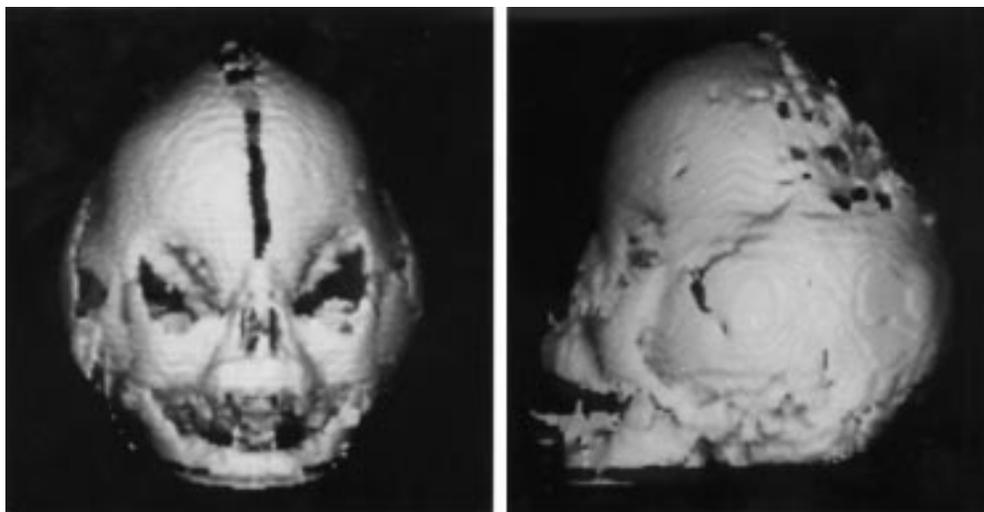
Cranial 3D CT scan of the patient, front and lateral view.
